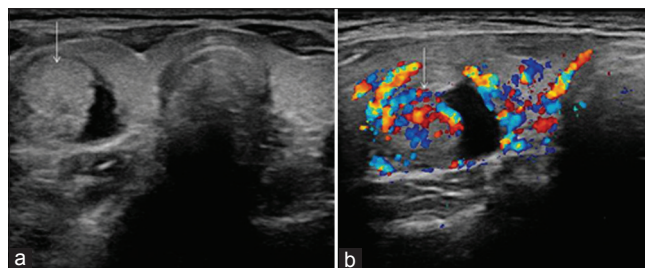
Benign cystic colloid nodule in a 55-year-old female patient. Transverse sonogram neck (a) reveals a well-circumscribed right-sided cystic nodule with solid peripheral component and 'ring down' artifact (thin arrow). The lesion demonstrates a thin hypoechoic rim (thick arrows) and posterior acoustic enhancement. Color Doppler image (b) demonstrates vascularity in the solid peripheral component. (Reproduced with permission from Indian Journal of Endocrinology and Metabolism)
